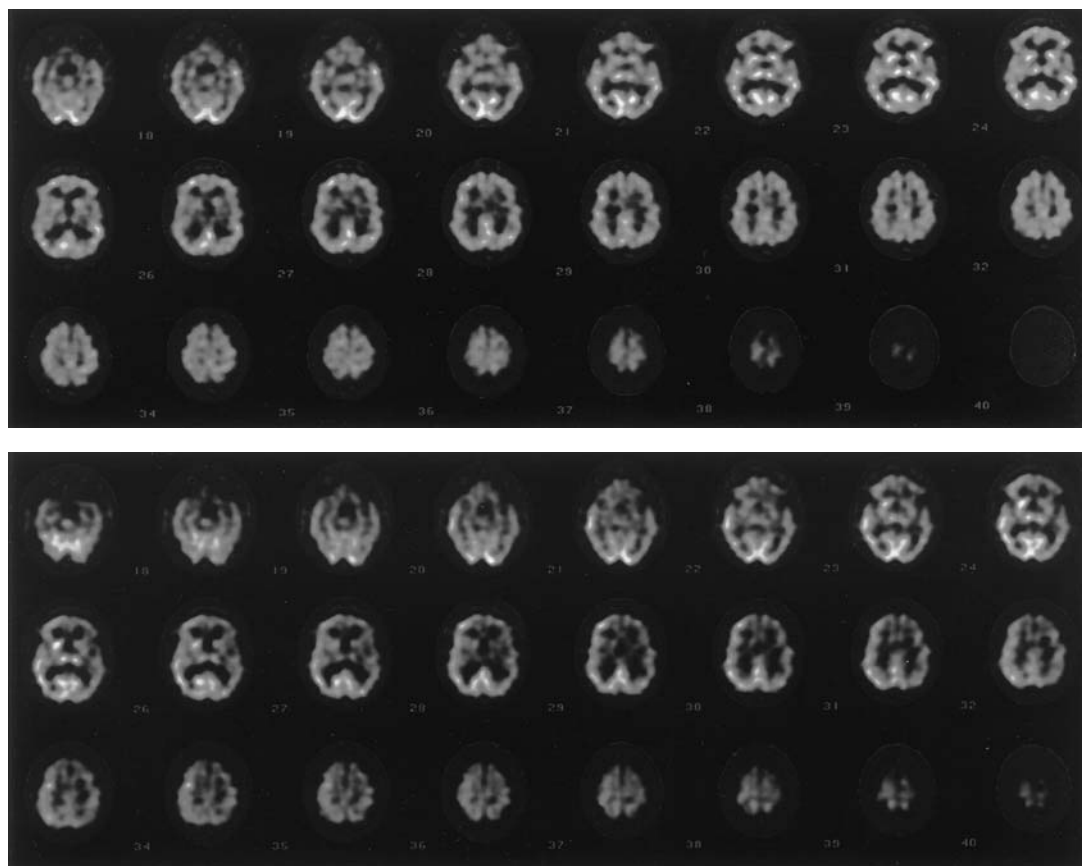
Baseline SPECT imaging in a patient with bilateral carotid occlusions and symptomatic left hemispheric ischemic spells, demonstrating normal and symmetric uptake bilaterally. SPECT imaging in the same patient after acetazolamide administration, demonstrating decreased left hemispheric uptake. The patient was treated with left-sided STA–MCA bypass surgery. SPECT, single photon emission computed tomography; STA, superficial temporal artery; MCA, middle cerebral artery.
